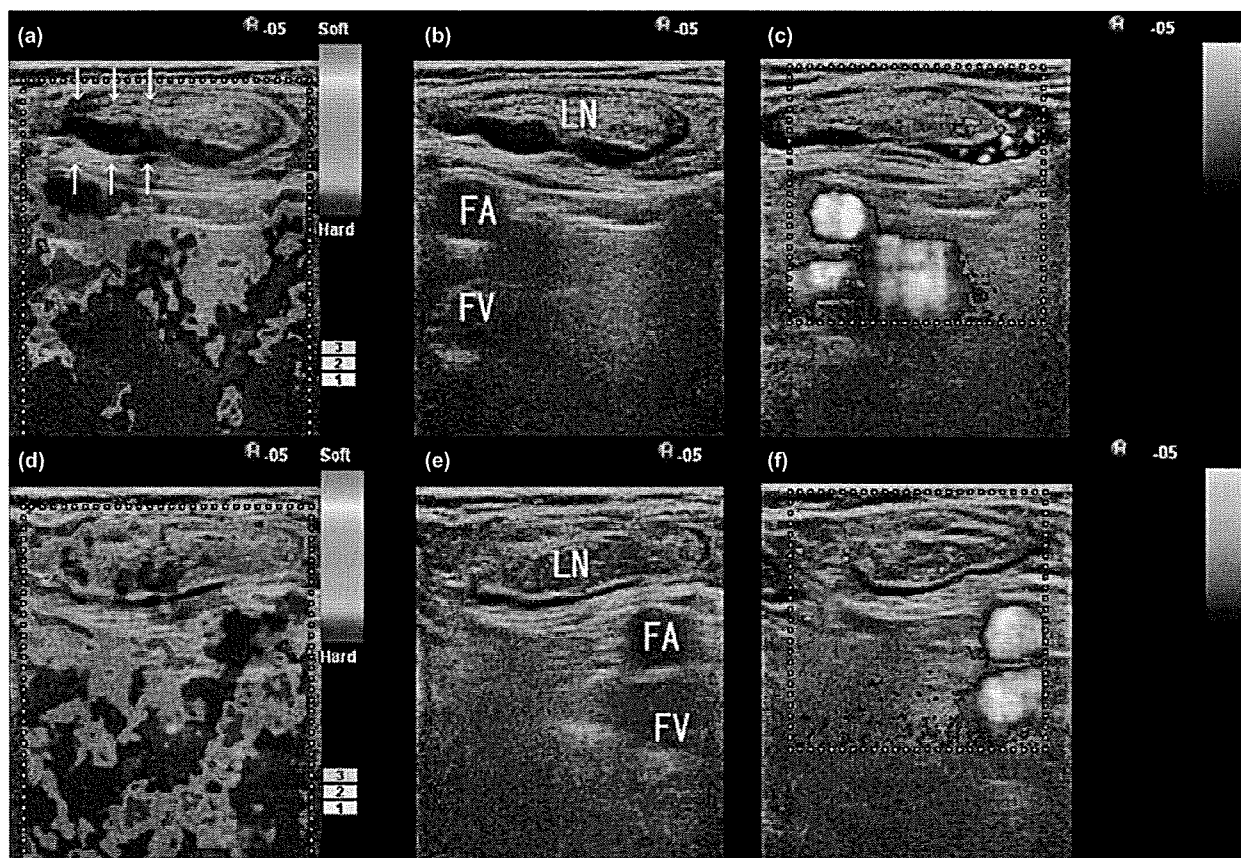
(a–c) Right inguinal lymph node visualized by (a) elastography, showing asymmetrical areas of high elasticity appearing as deep blue in the cortical area (arrows); (b) B-mode sonography; and (c) power Doppler sonography, showing presence of peripheral flow. (d,e) Left inguinal lymph node visualized by (d) elastography, showing several small areas of high elasticity appearing as blue; (e) B-mode sonography; (f) power Doppler sonography, showing weak central hilar and perihilar flow. FA, femoral artery; FV, femoral vein; LN, lymph node.
